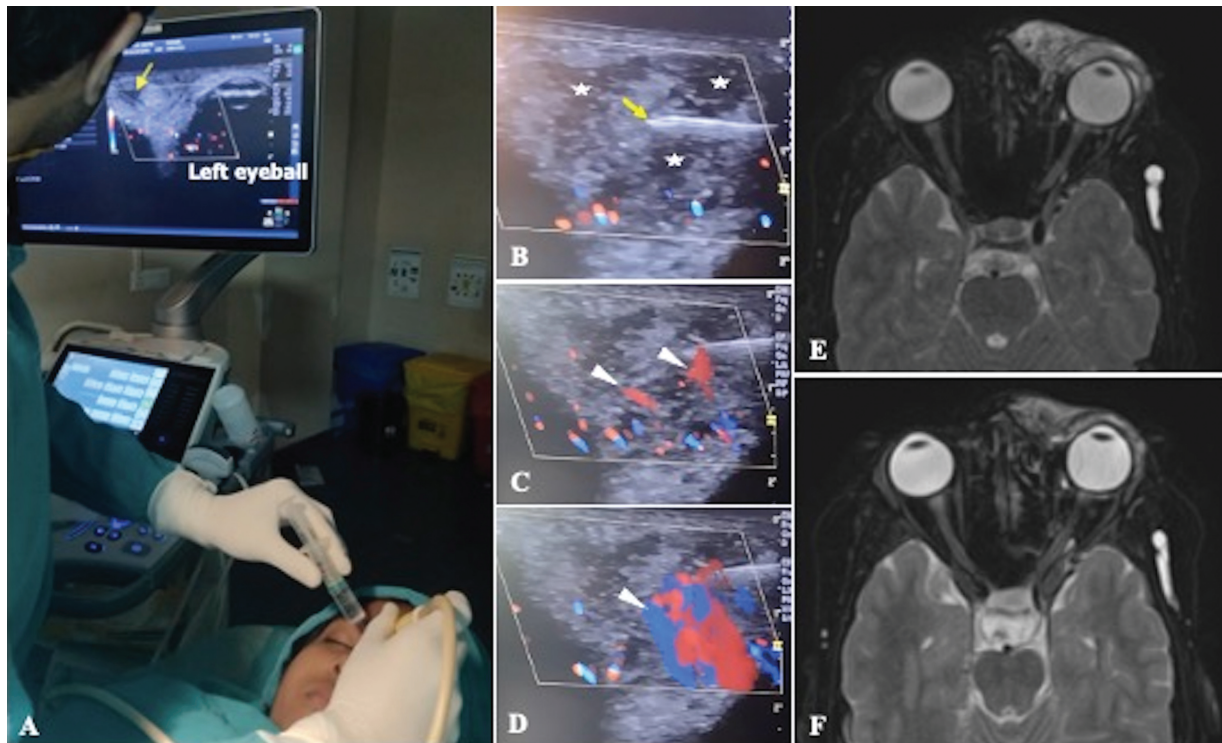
(A–D) Snapshots of real-time Doppler-guided injection in the medial preseptal lesion. Notice the needle as a white reflecting line (arrow), the left eyeball shadow, the relatively avascular cystic spaces (stars), and the influx of the drug (arrowheads); (E) pre- and (F) postsclerotherapy axial T2 fat saturation (FAT-SAT) magnetic resonance imaging (MRI), showing moderate reduction in the preseptal component at 6 months' follow-up. The postseptal component along the medial extraconal compartment has also reduced.
